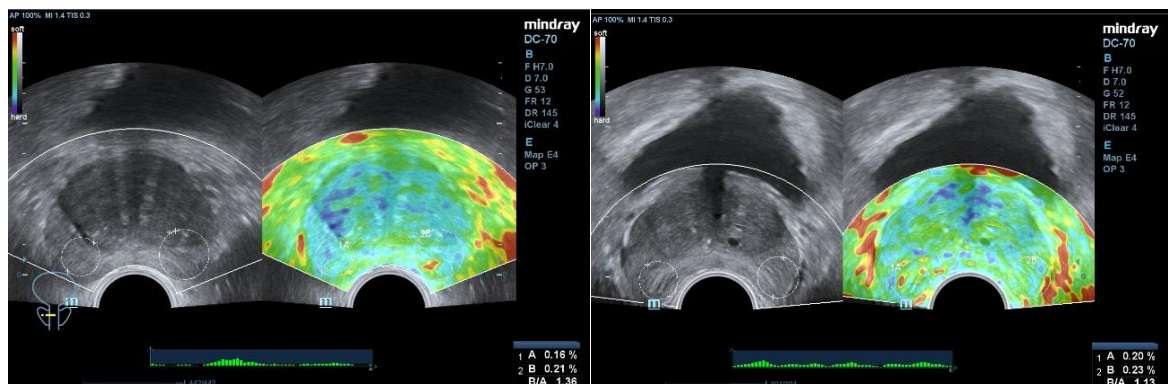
Benign prostatic hyperplasia (BPH). Transrectal ultrasound (TRUS) in the compression elastography mode.
